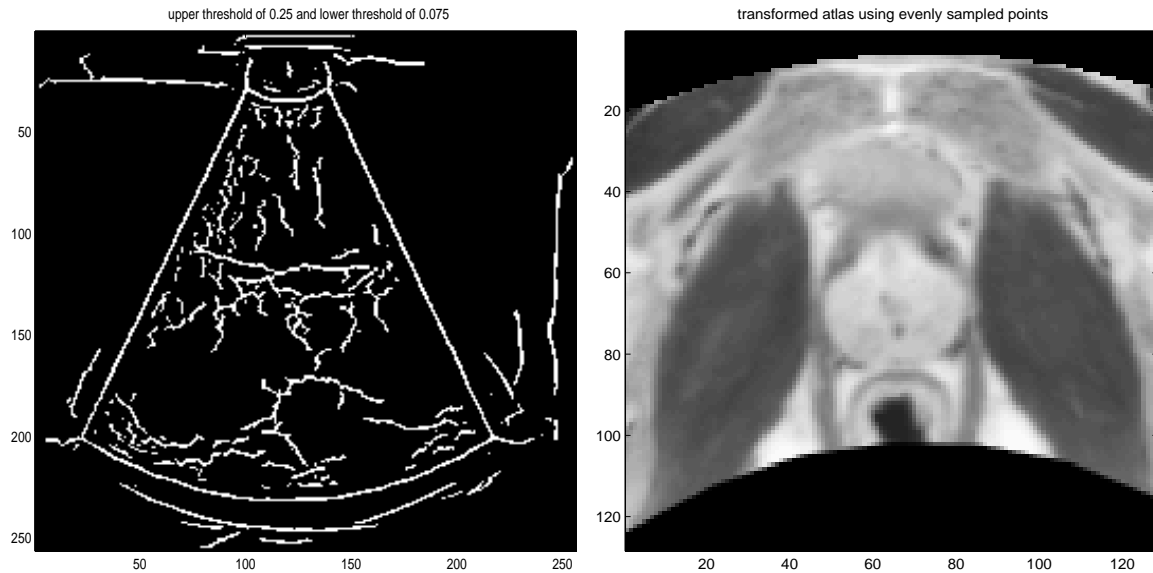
Ultrasound edges from phase congruency (left) and CT/MR registration results using 132 corresponding points (right)
